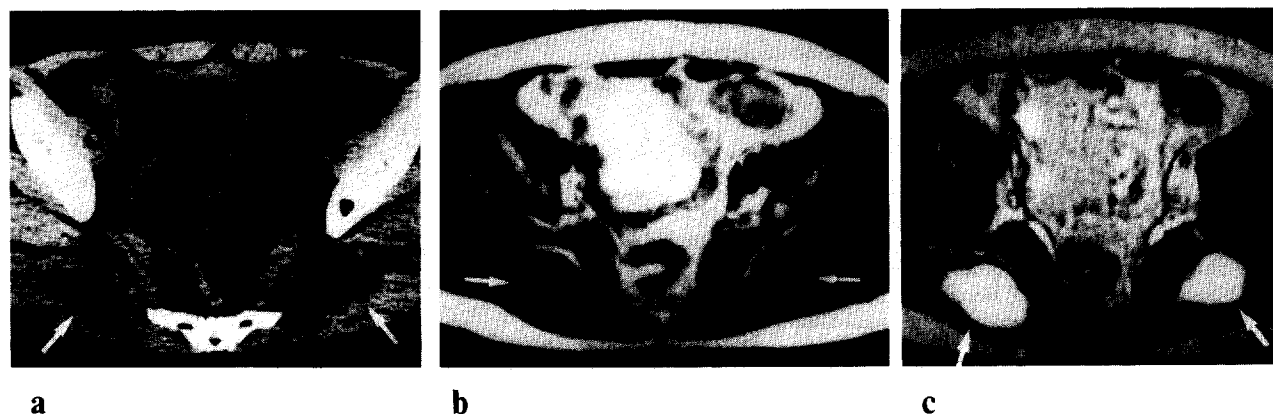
(a) CT scan reveals oval water density lesions (white arrows) in the bilateral hips. (b) MR axial T1-weighted and (c) T2-weighted images demonstrate the lesions (white arrows) with water signal intensity in the bilateral hips.
